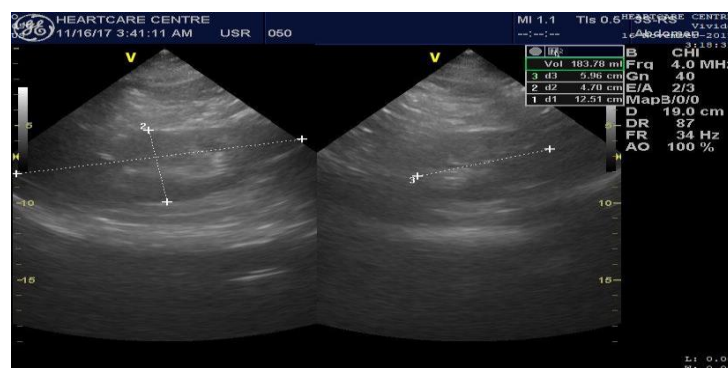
Longitudinal and transverse ultrasound images of an enlarged left kidney measuring 12.51 cm in a 60 year old female with HIV
